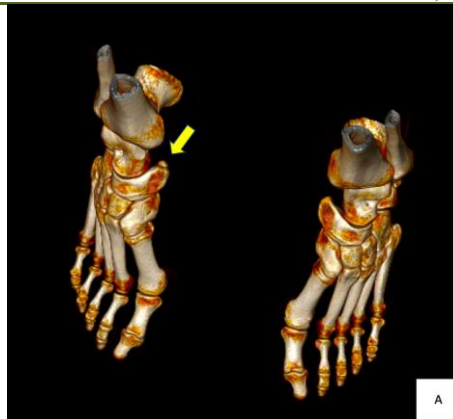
Three-dimensional CT volume-rendered reconstruction of both feet demonstrating a right medial accessory navicular bone adjacent to the navicular tuberosity, consistent with a type II accessory navicular
